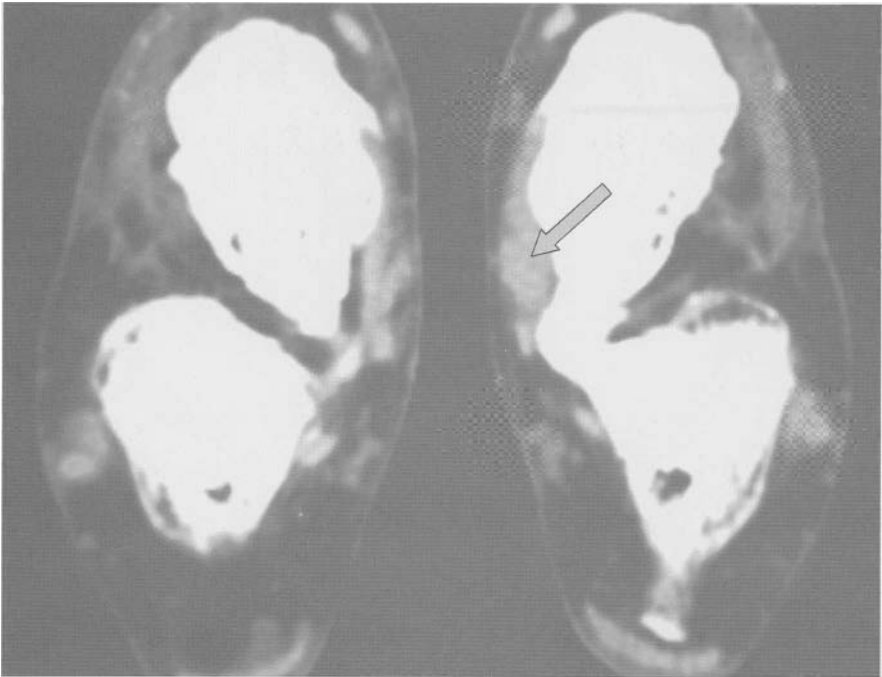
CT soft tissue window. Left pt: stage 1 tendinopathy (arrow).
